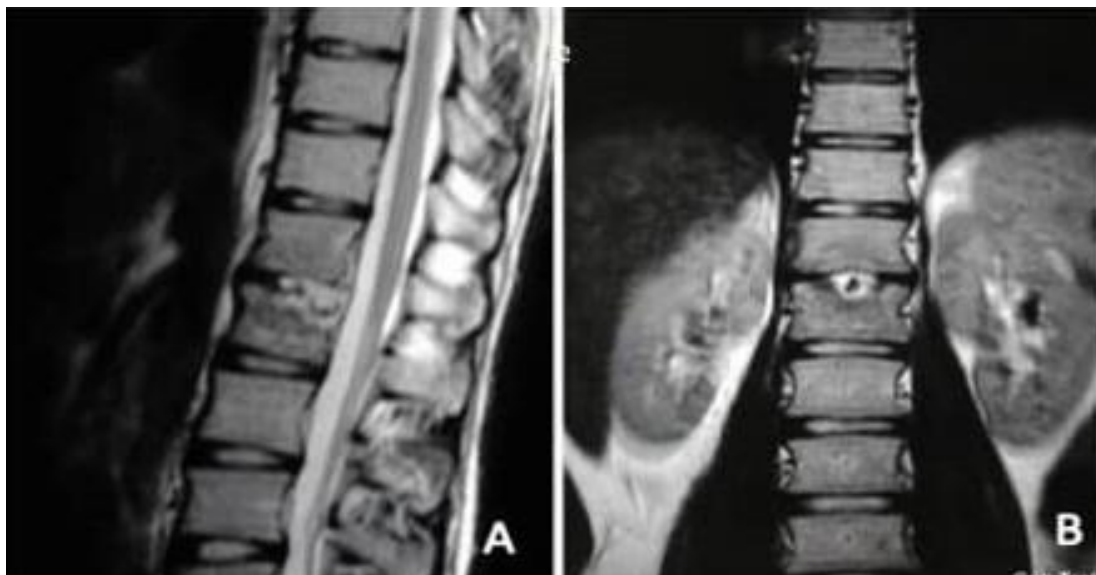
MRI showed disease control after 6 months of laparoscopic surgery. Right kidney was back to its normal place and no abscess were observed in the bilateral psoas muscles in the coronal plane
